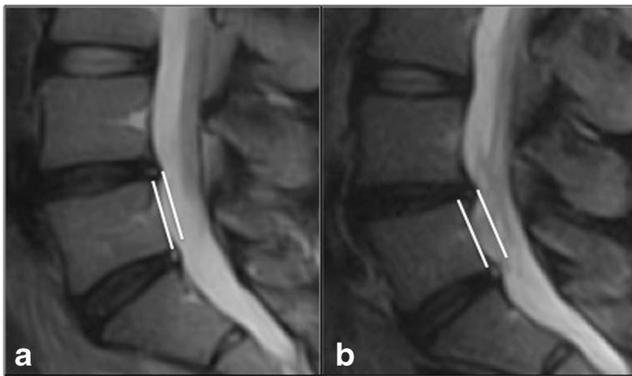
Sagittal T2-weighted TSE in supine (a) and upright (b) standing. Disc bulge of L4-L5 is increased in b (white lines)
